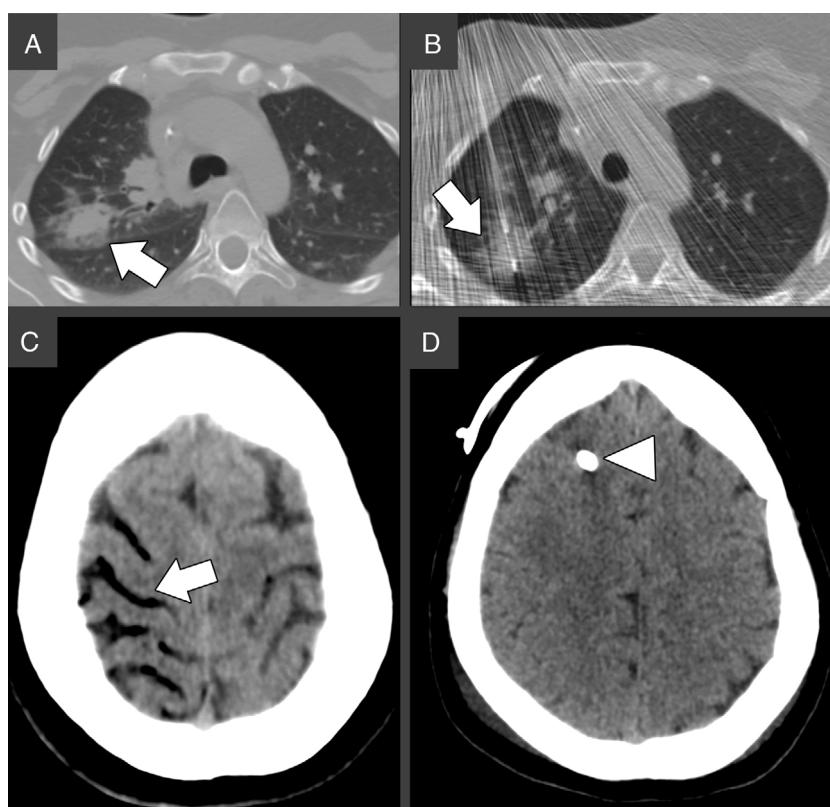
(A) Chest CT prior biopsy. The white arrow indicates the target lesion in the right upper lobe, in close proximity to the main fissure. (B) Chest CT during the biopsy. An 18-gauge Tru-Cut needle is successfully advanced through the target nodule under continuous CT-fluoroscopy guidance, as indicated by the white arrow. (C) Brain CT 19 min after the biopsy. The white arrows indicate air in the right superior frontal, precentral, central (A) and superior temporal (B) sulci, consistent with cerebral venous air embolism. (D) Brain CT 3 days after biopsy showing complete resorption of the air bubbles. The white arrowhead indicates the external ventricular derivation.
